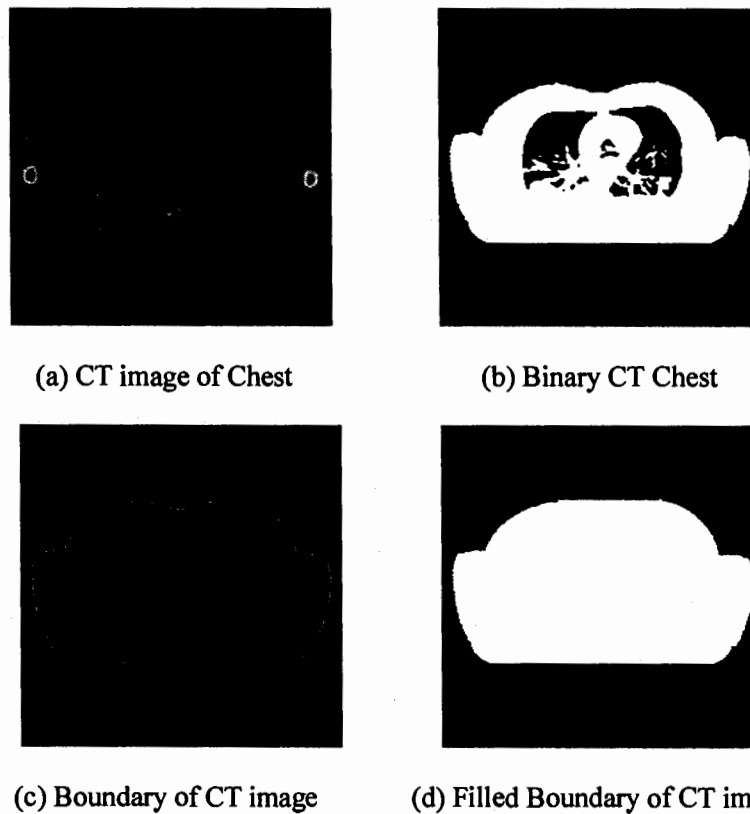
Steps to make foreground as a single region in CT image of Chest
